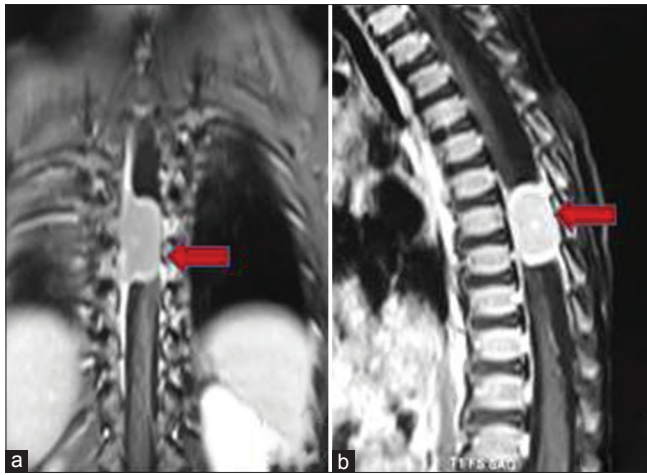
Magnetic resonance imaging T1-weighted post contrast images of dorsal spine coronal (a) images reveal an intradural well defined ovoid lesion along D6 to D8 spine (red block arrows). There is homogenous postcontrast enhancement with hyper enhancing rim. Magnetic resonance imaging T1-weighted postcontrast images of dorsal spine sagittal (b) images reveal an intradural well defined ovoid lesion along D6 to D8 spine (red block arrows). There is homogenous post contrast enhancement with hyper enhancing rim
